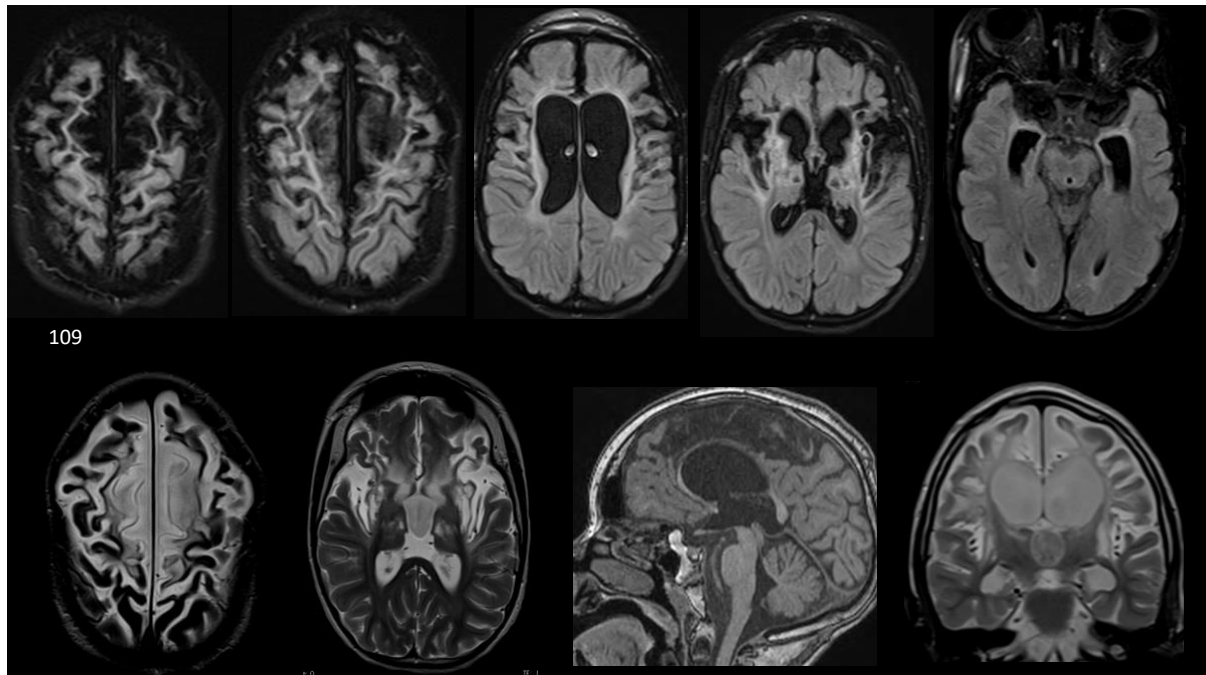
Collage of MRI images obtained for patient 109
